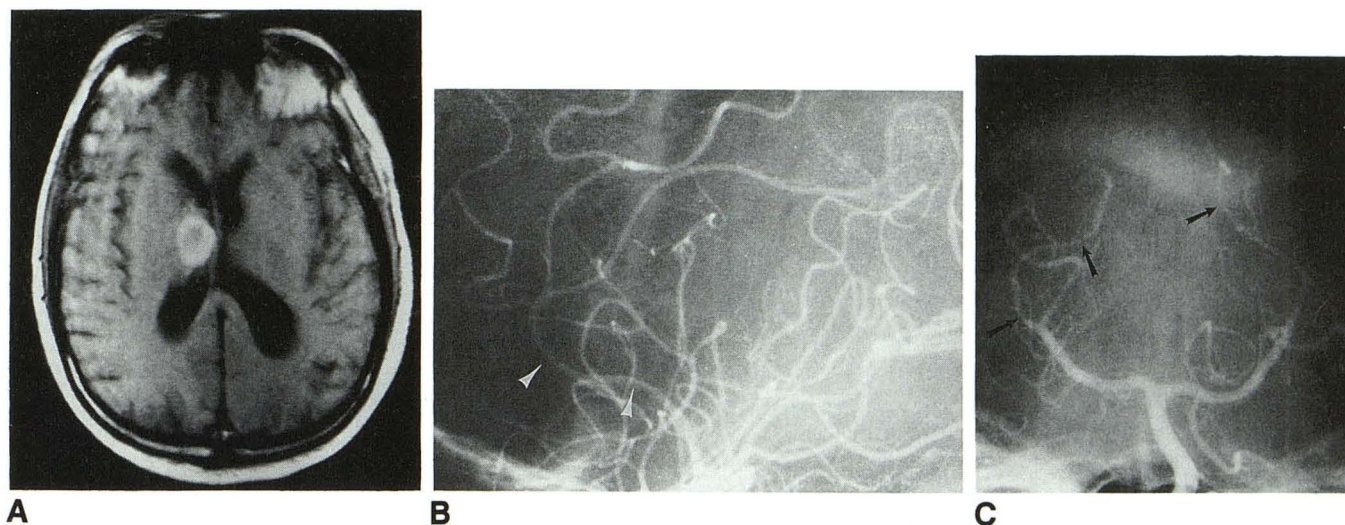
Patient 8: Systemic vasculitis. This 68-year-old man had headache, myalgia, and gait disturbance. A, Axial T1-weighted MR image shows hyperintense right thalamic hemorrhage. B, Lateral projection from right internal carotid arteriogram shows narrowing of anterior cerebral artery (arrows). C, Anteroposterior projection from left vertebral arteriogram shows narrowing and attenuation of both posterior cerebral arteries (arrows).
